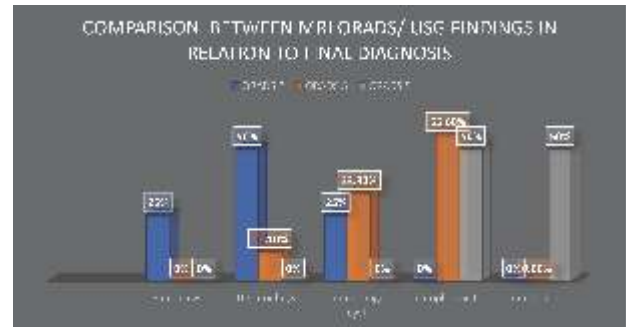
Final Diagnosis in Comparison to MRI O-RADS and USG Findings (% frequency)
